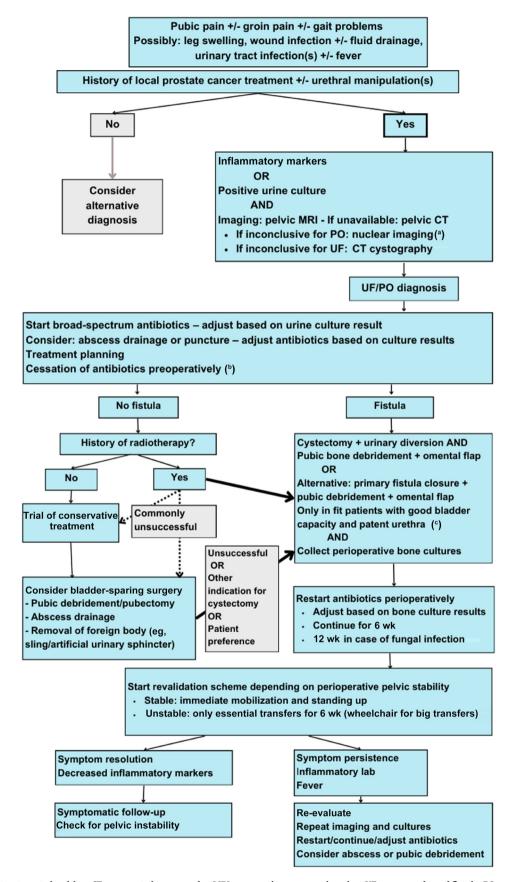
Proposed treatment algorithm. CT = computed tomography; MRI = magnetic resonance imaging; UF = urosymphyseal fistula; PO = pubic osteomyelitis.
